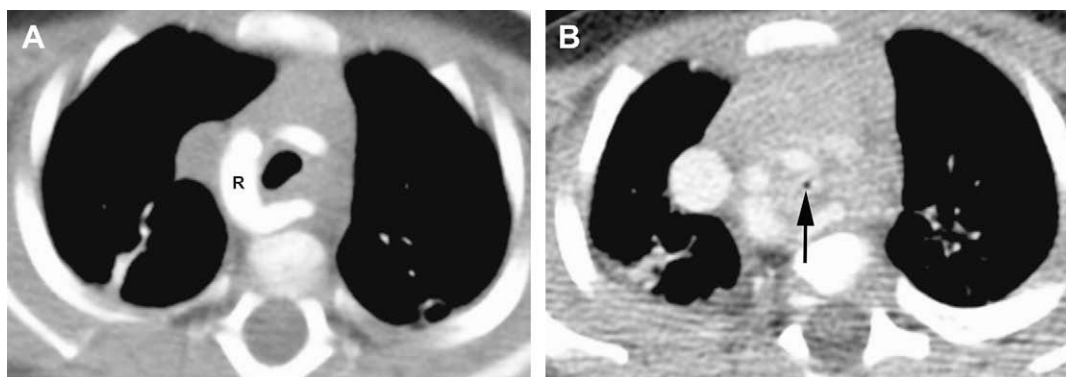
TM in a young child associated with extrinsic compression from mediastinal vascular anomaly. Inspiratory contrast-enhanced CT image (A) demonstrates mild tracheal compression from a right-sided aortic arch (R) with aberrant left subclavian artery. Dynamic expiratory CT image (B) at similar level demonstrates near collapse of the trachea (arrow), consistent with severe TM. Prominent thymic tissue is noted in the mediastinum, consistent with the patient's young age.
